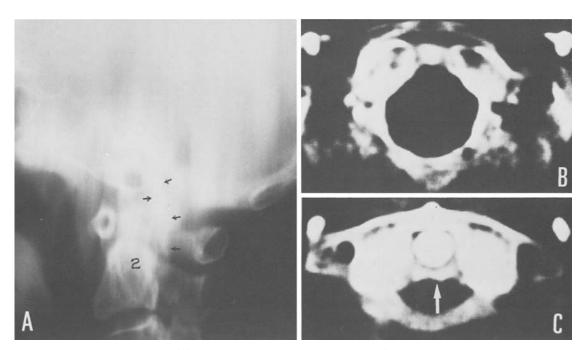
Cervical spine laminogram (A) with radiopaque lesion behind the dens (small black arrows) compressing medullospinal junction in a case with spastic tetraparesis and the CT (B, C). The CT slices, 5 mm in thickness, were sectioned parallel with a line -10° from RBL. Note, in C, a hemicircular band-shaped high (EMI-unit: +445) density (white arrow) indicating ossified transverse atlantal ligament which clearly explain the lesion and the mechanism of cord compression. Margin and bone at and around the foramen magnum is well demonstrated in B.
